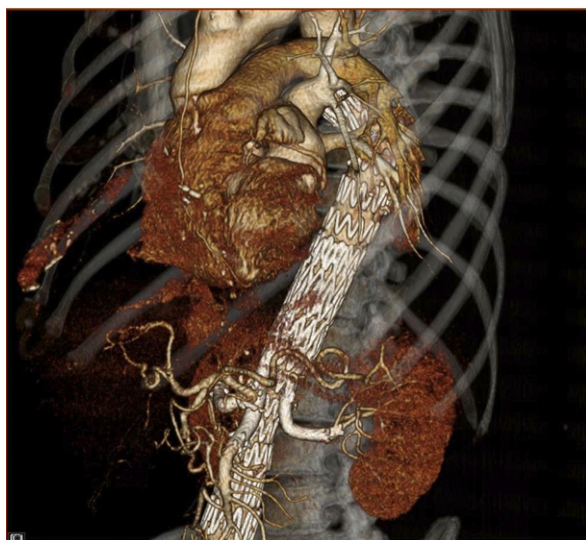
Four-month follow-up computed tomography showing exclusion of the aneurysm and preservation of blood flow to both kidneys and the superior mesenteric artery.
